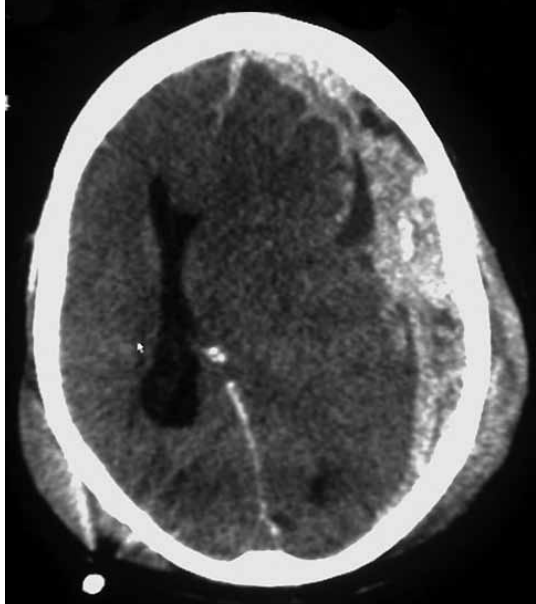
Here is an example of a cross-section of a person’s brain produced by a CT scanner. Note that the image is not in colour. Images can be checked by technicians for bone abnormalities, fluid retention, tumours, haemorrhages, trauma or skull fractures among other things. In this image, the darker areas in the upper right indicate the presence of subdural (beneath the skull) trauma or blood clotting.
